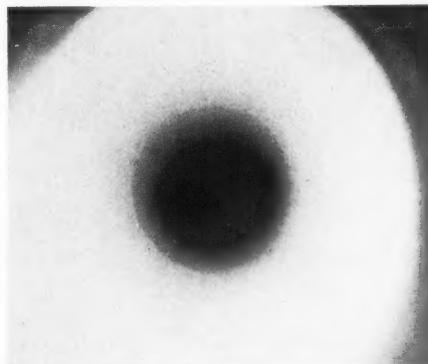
Radiograph of pervaginal beam at surface of cervix uteri. Diameter of main beam 5.5 cm.
